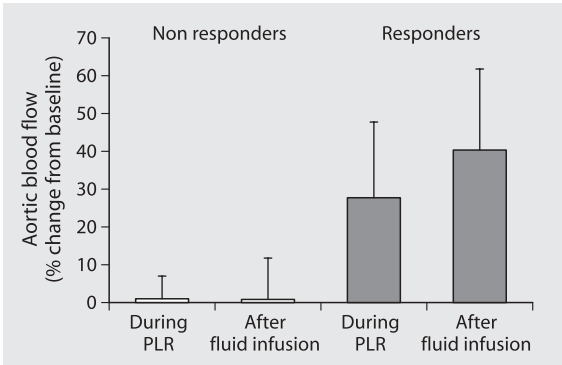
Prediction of fluid responsiveness by passive leg raising (PLR) and esophageal Doppler in the critically ill. In 71 critically ill patients with acute circulatory failure, the aortic blood flow was measured by esophageal Doppler during a passive leg raising test and after fluid infusion [11]. In patients who did not respond to fluid infusion (non-responders, $n=34$, open bars), passive leg raising did not alter the aortic blood flow significantly before fluid infusion. Conversely, in patients who responded to fluid infusion by
